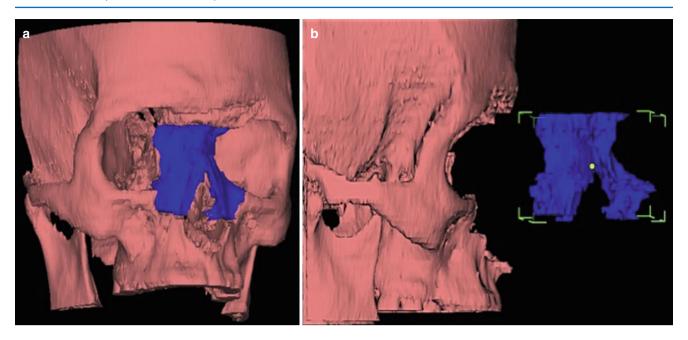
Three-dimensional CT images (a, b). The fracture complex has been highlighted. In this case there is relatively little comminution
